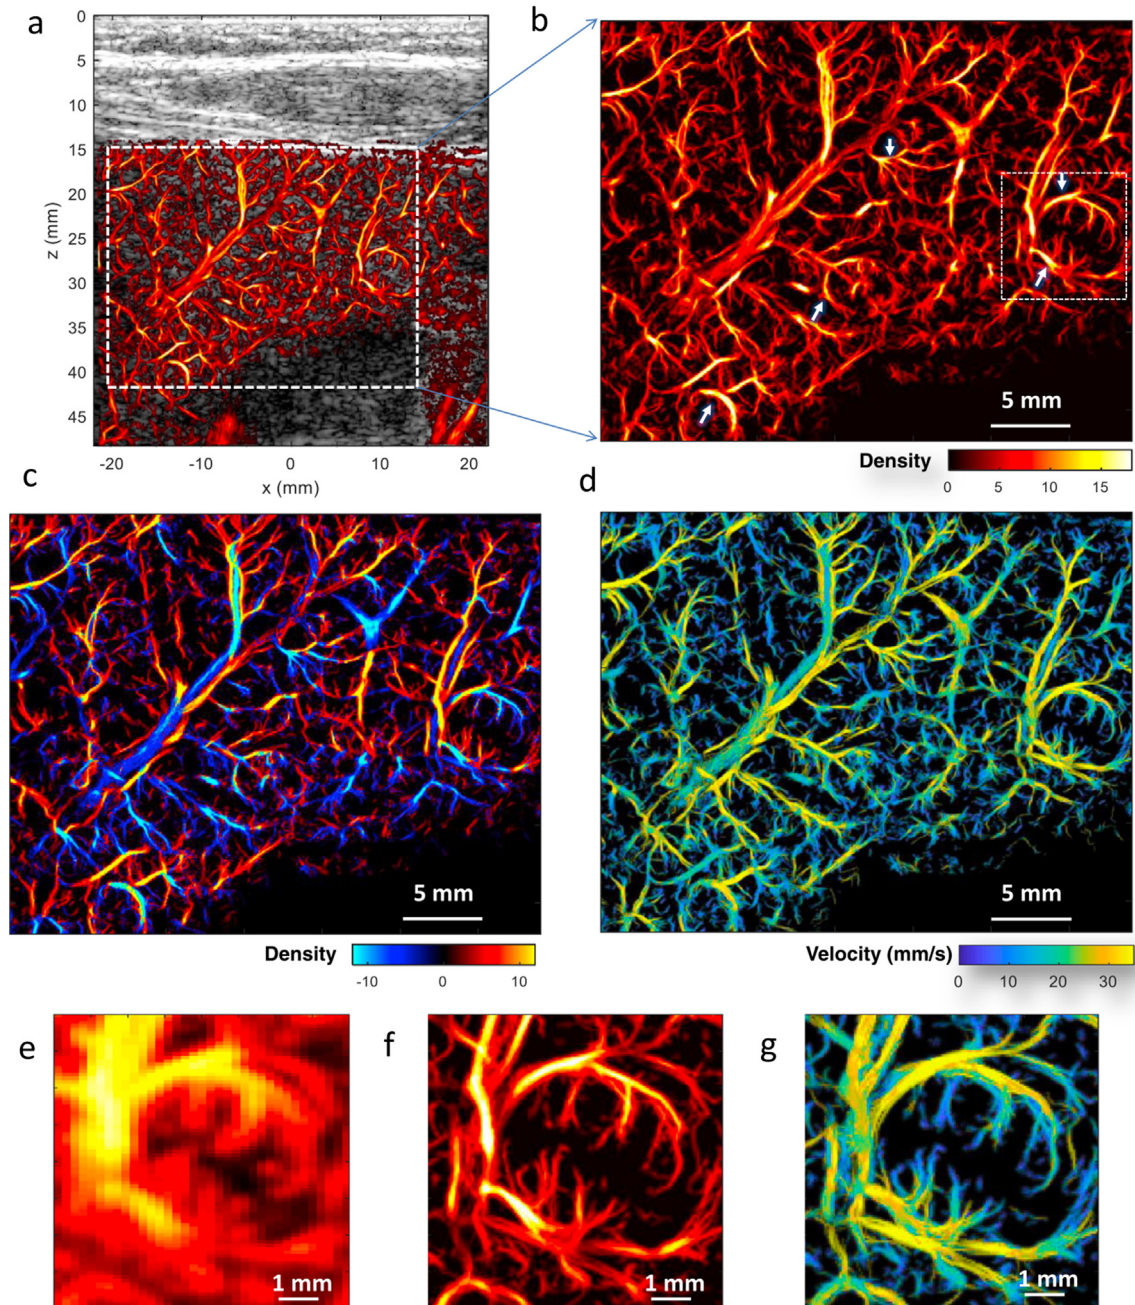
In vivo* human liver super-resolution imaging from a 38 year old patient with acute-on-chronic liver failure. (a) Super-resolved liver microvascular image overlaid on the B-mode image; (b) magnified view of the region indicated by the white dashed box in (a); (c) directional microvessel density map (red color indicating bottom-top flow direction and blue color indicating top-bottom flow direction); (d) super-resolved flow velocity map; (e) – (g) power Doppler, super-resolved vessel density, and flow velocity map of a local region marked by the white dashed box in (b). The white arrows denote distorted vessels with tortuosity and/or tapering in the main branches. (Images reprinted from Huang *et al.*, 2021 [62]).
